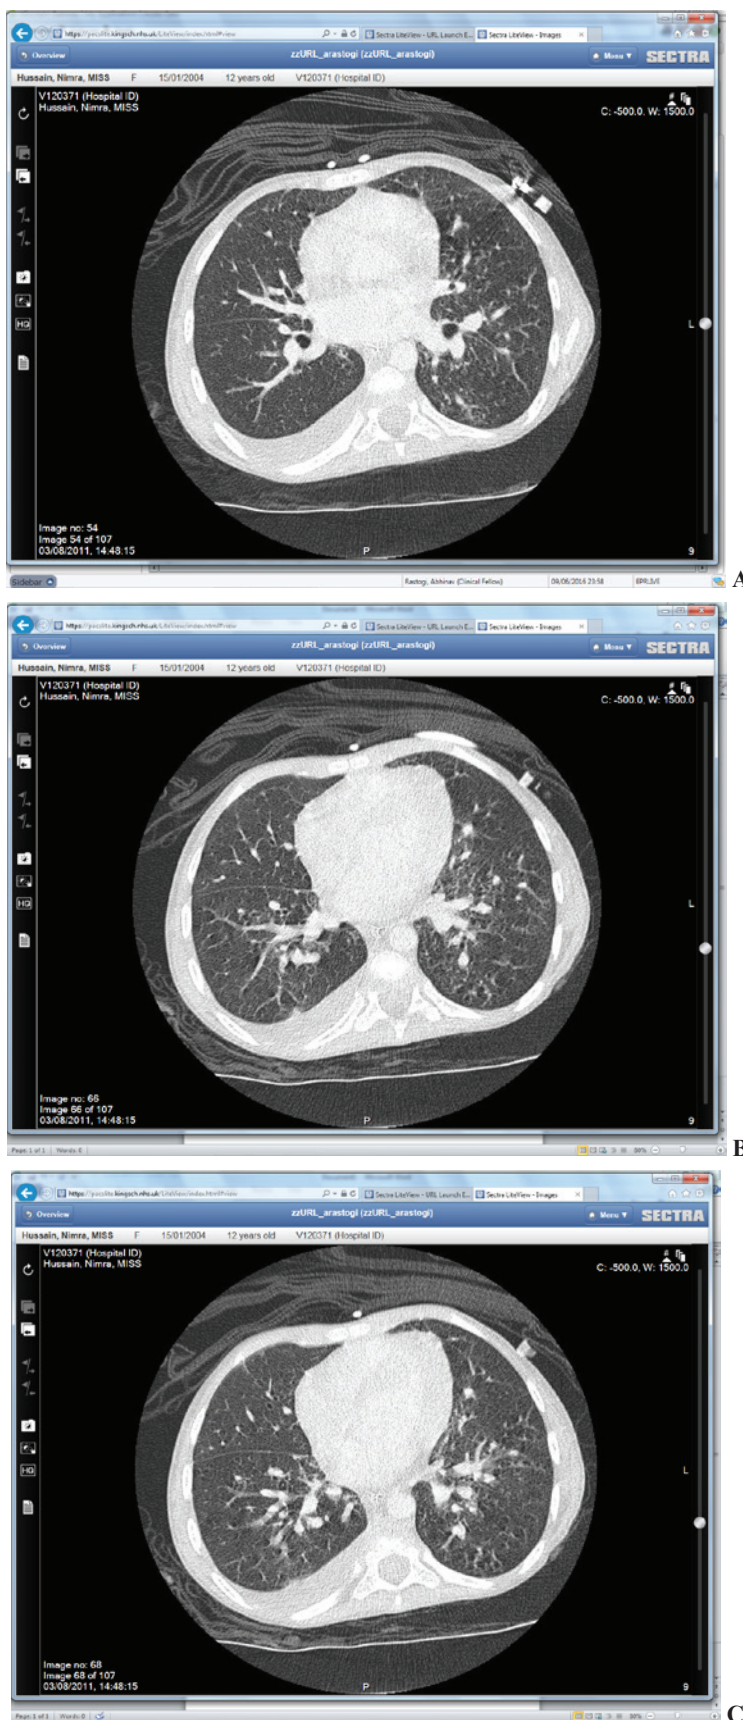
Axial computed tomography angiography images using intravenous contrast below the level of carina (A) towards the base (B, C).
